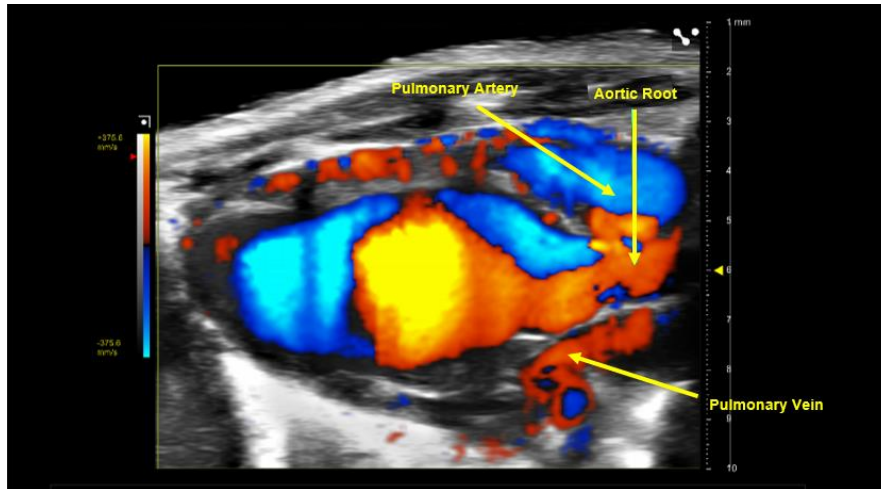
Aortic root in Color EKV Doppler (Color EKV is not available on Vevo ultrasound systems released before the Vevo F2)
